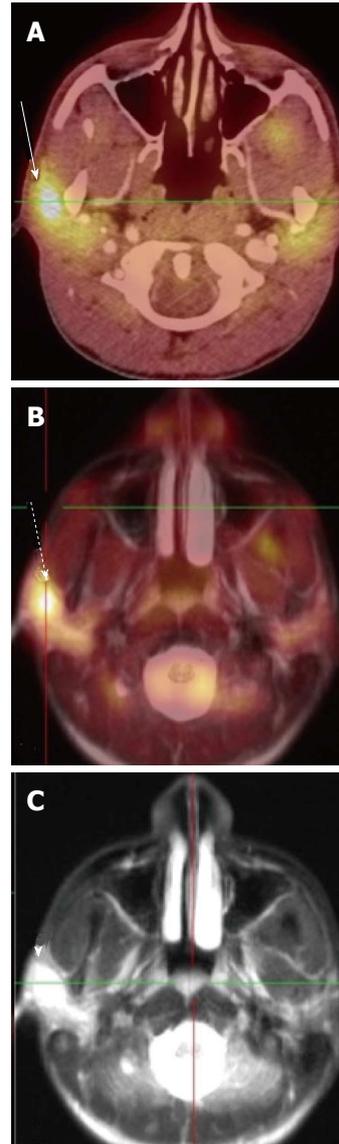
18-year-old male with follicular lymphoma of the right parotid gland. Axial fused PET-CT image (A) shows intense uptake in the region of the right parotid gland (white arrow). Axial fused PET-MRI image (B) (T2 HASTE sequence) shows similar intense uptake in the right parotid (yellow image). Axial T2 HASTE image (C) shows a focal T2-hyperintense mass in the right parotid. This mass was not well seen on CT. PET-MRI: Positron emission tomography-magnetic resonance imaging; CT: Computed tomography.
